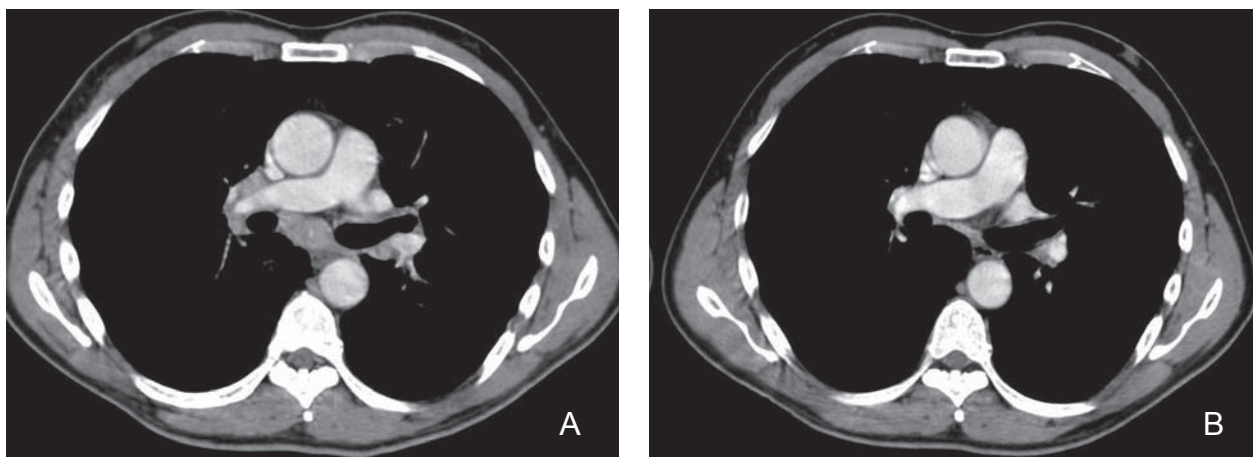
Computed tomographic scan results showed mediastinal and hilar lymphadenopathy (A). No lymph node swelling was observed one year after discontinuation of interferon treatment (B).
